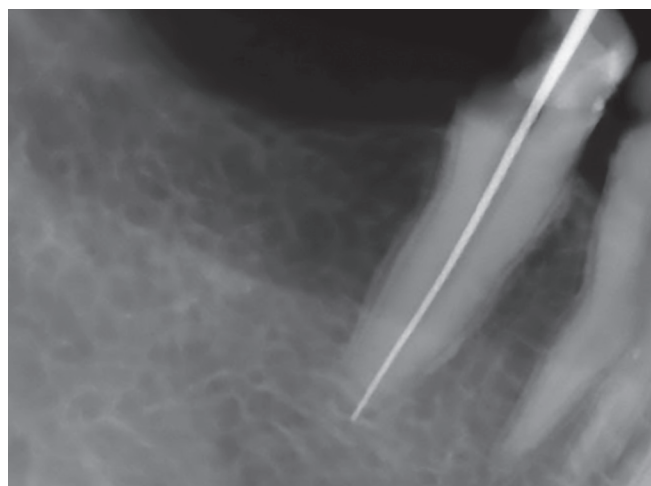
Working length radiograph of tooth #45 with single canal
